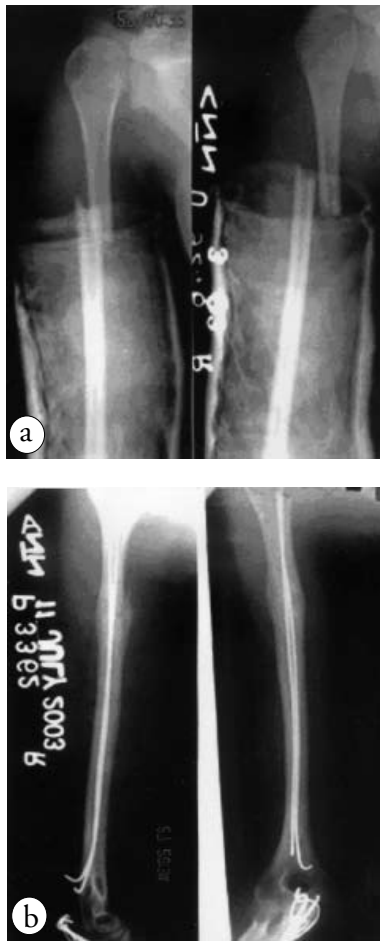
Radiographic image a) on the day of trauma (fracture shaft of humerus at the junction of proximal approximately one-third and distal of two-thirds) b) on the 16 weeks after the operation (fracture was united with k-wires in situ).
